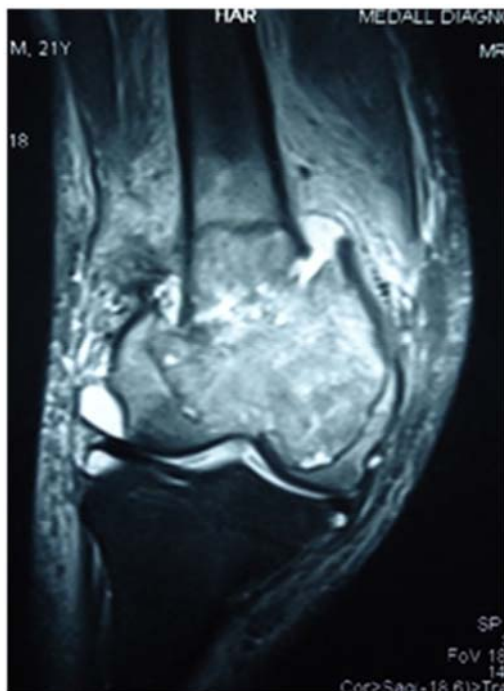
MRI images of knee joint, showing pathological fracture of distal femur due to giant cell tumor, marrow replacement can be noticed.
